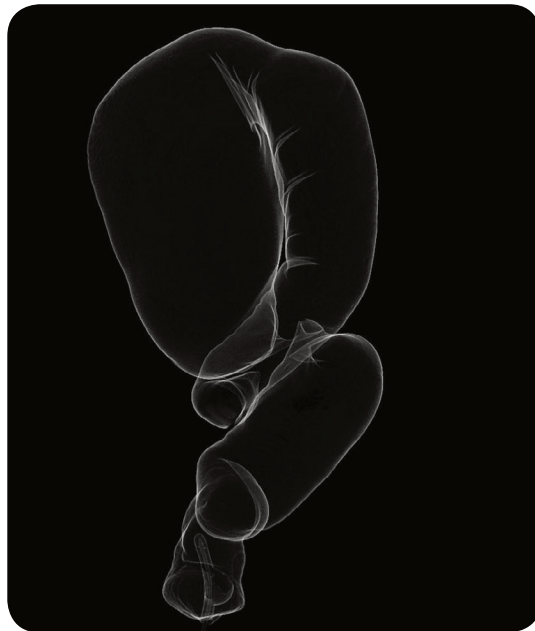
3D CT virtual colonoscopy demonstrating sigmoid volvulus.
